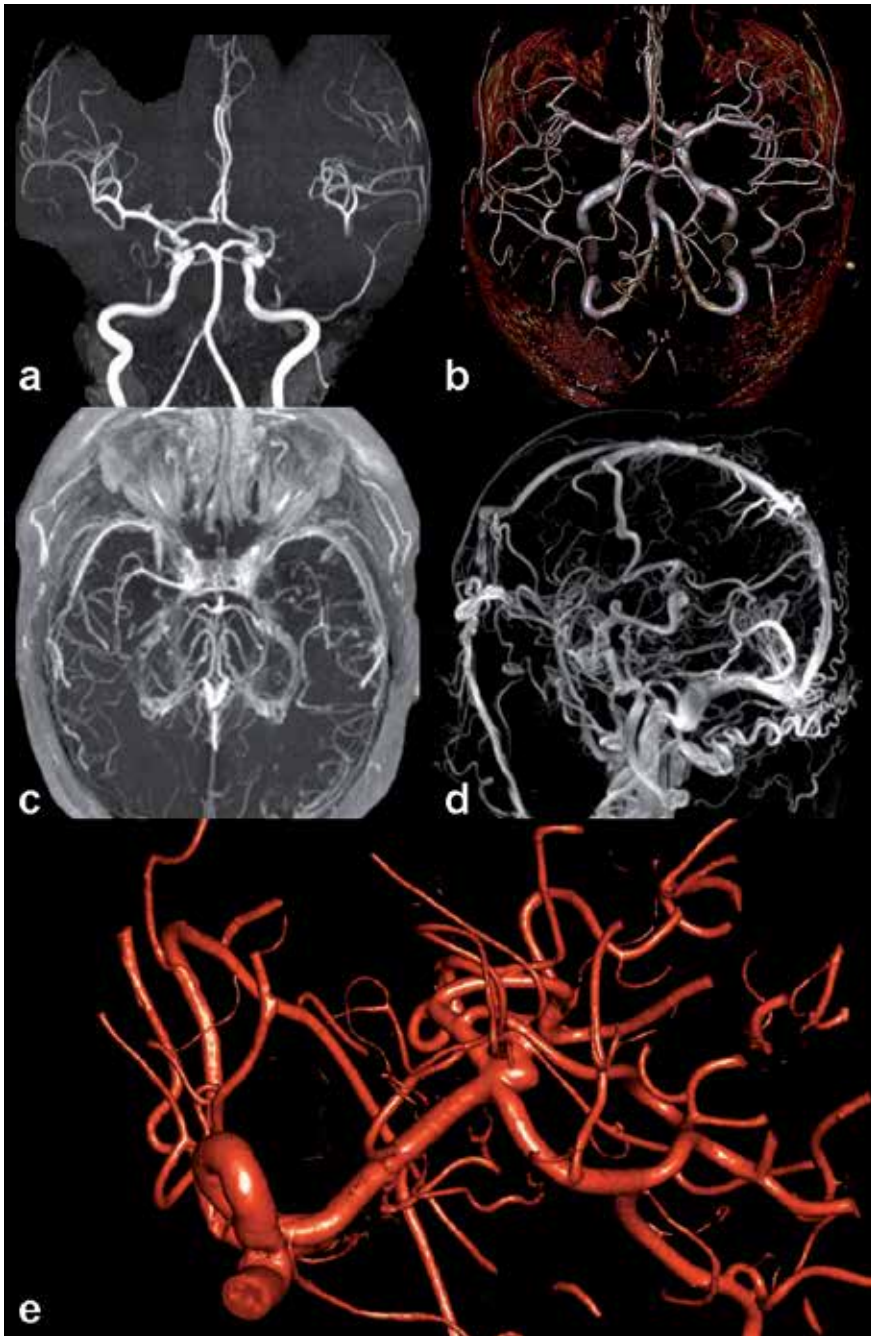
On the coronal thick MIP (a), colored axial VR (b), posterior fossa axial thin MIP (c), sagittal thick MIP and (d) MRI imaging of different cases, it is conspicuous that extremely complex network can also be visualized in detail. Despite the advanced MRI technology, it is understood that more complex traces can be visualized with higher quality which is shown on the VR/3D biplane angiographic image.
